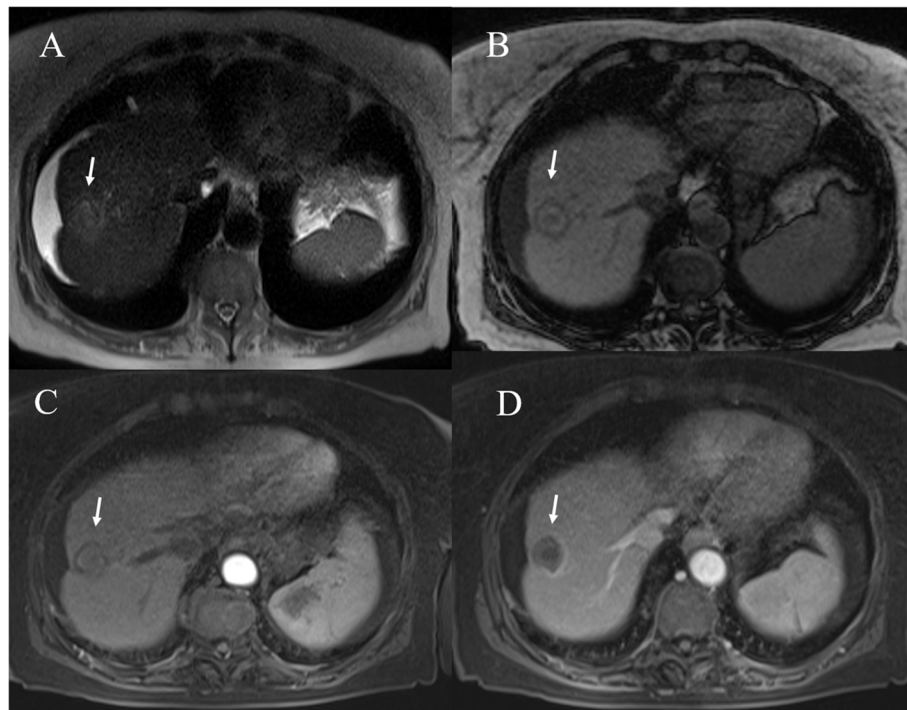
Post RFA MRI assessment of HCC on VIII hepatic segment. The ablated lesion is non viable with isointense signal in T2-W (A) sequence, targetoid appearance in T1-W (B and C) sequences and no hypereenhancement during arterial phase (D) of contrast study
